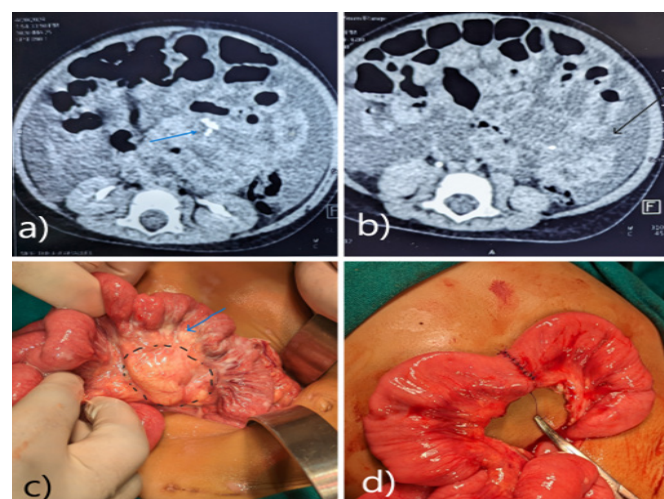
CT images and intraoperative photographs of the cystic lesion with chylous fluid: a) Axial CT cut with calcified mass in the mesentery (blue arrow) b) CT image with ascites (black arrow). c) cystic lymphatic mass in the mesentery and d) Bowel with mesenteric defect after resection and anastomosis.
